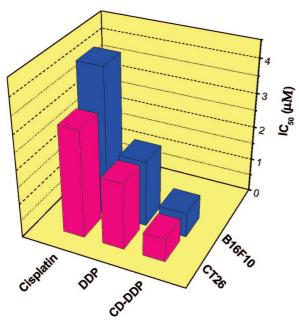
3D plot showing the IC₅₀ values of CPT, DDP, and CD-DDP inclusion complex in CT 26 and B16F10 cell lines.
